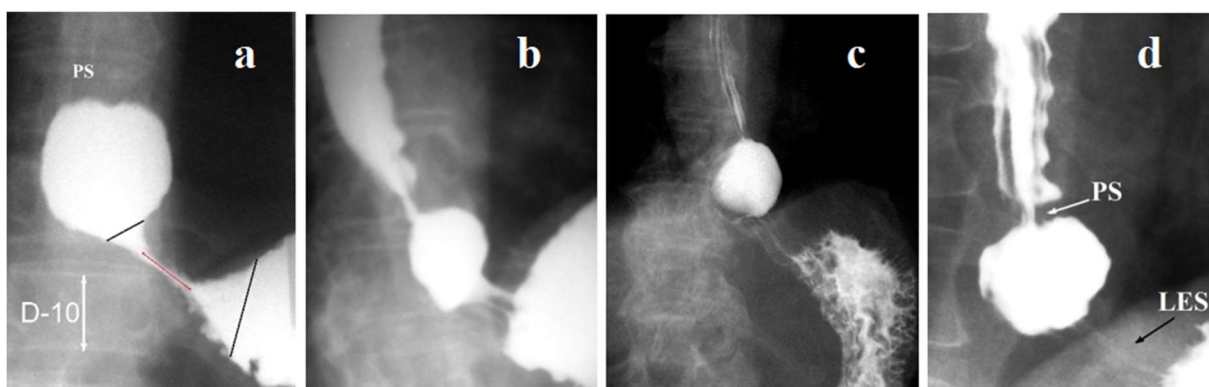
EGJ radiographs of patients with GERD took ≈ 30 seconds from the start of abdominal compression. In all cases, abdominal compression resulted in a reflex contraction
